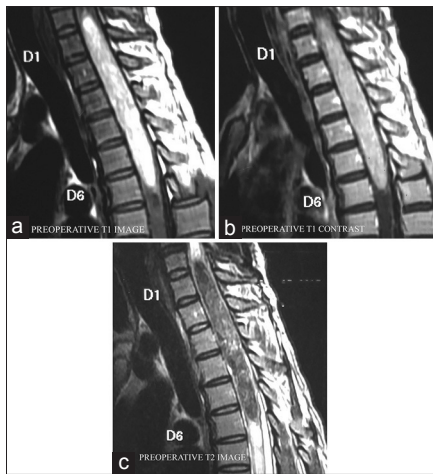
(a) Preoperative T1-weighted magnetic resonance imaging, (b) preoperative magnetic resonance imaging T1 with gadolinium, (c) preoperative magnetic resonance imaging T2-weighted image
